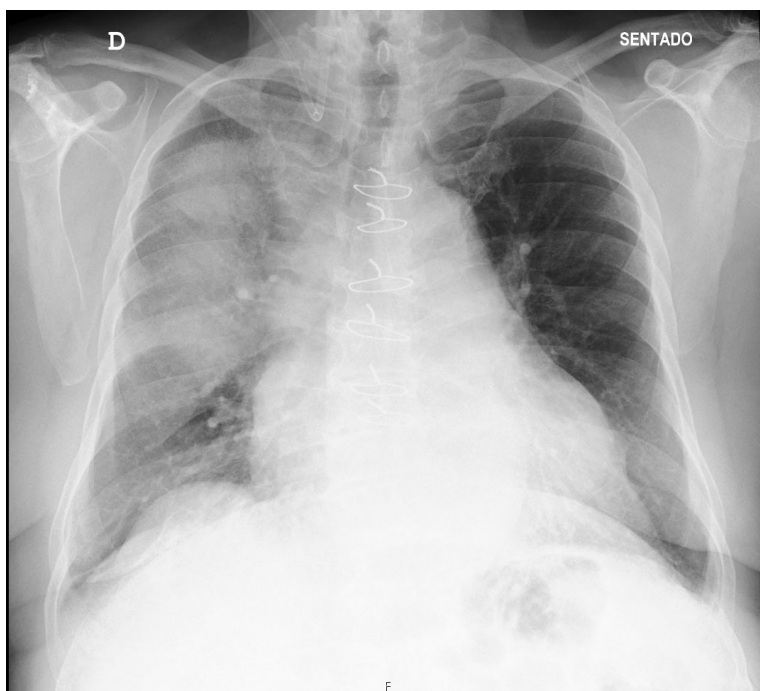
Chest radiography showing an extensive upper lobe opacity.
